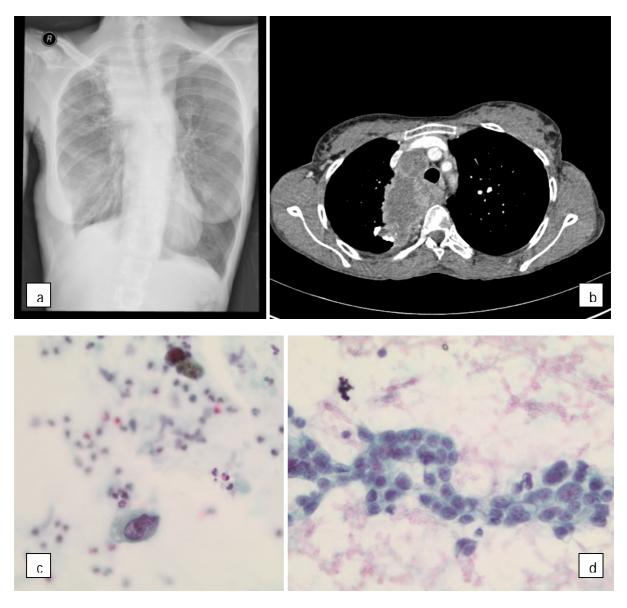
Large right hilar mass-nodal-complex extending to the apex of the right lung on chest X-ray (a) and CT (b). Sputum – malignant. Sparse, single cells predominantly with marked nuclear irregularities and vacuolated cytoplasm (c). TTNA - Well differentiated adenocarcinoma (d).
